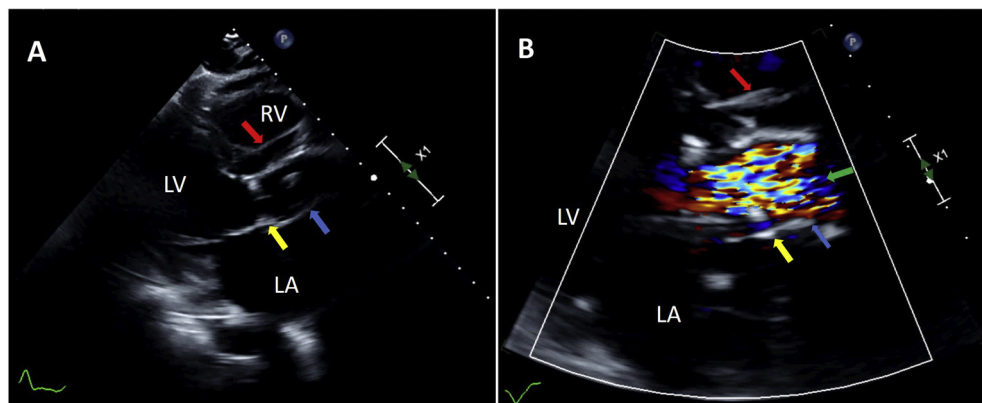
Transthoracic imaging was performed postoperatively. (A) A well-seated prosthetic aortic valve (*yellow arrow*) within the new prosthetic aortic root (*blue arrow*). The potential space created by the sealed pseudoaneurysm is visible (*red arrow*). (B) Color Doppler flow (*green arrow*) within the prosthetic aortic valve and root (*yellow and blue arrows*) but not within the old pseudoaneurysm (*red arrow*). LA, Left atrium; LV, Left ventricle; RV, right ventricle.
